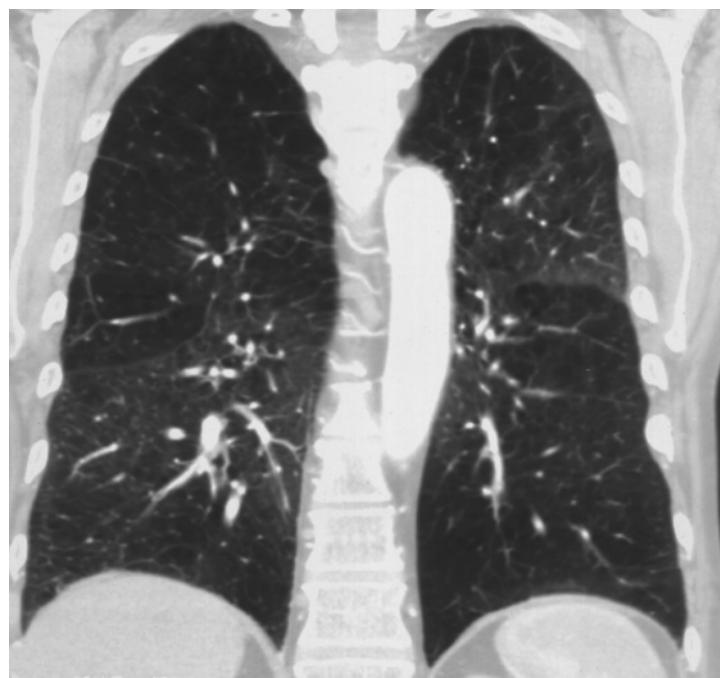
CT image of panlobular emphysema. The coronal reconstruction clearly visualizes apical hypodensities in both lungs as well as in the entire left lower lobe. Changes show more area consolidation than in centrilobular emphysema.
